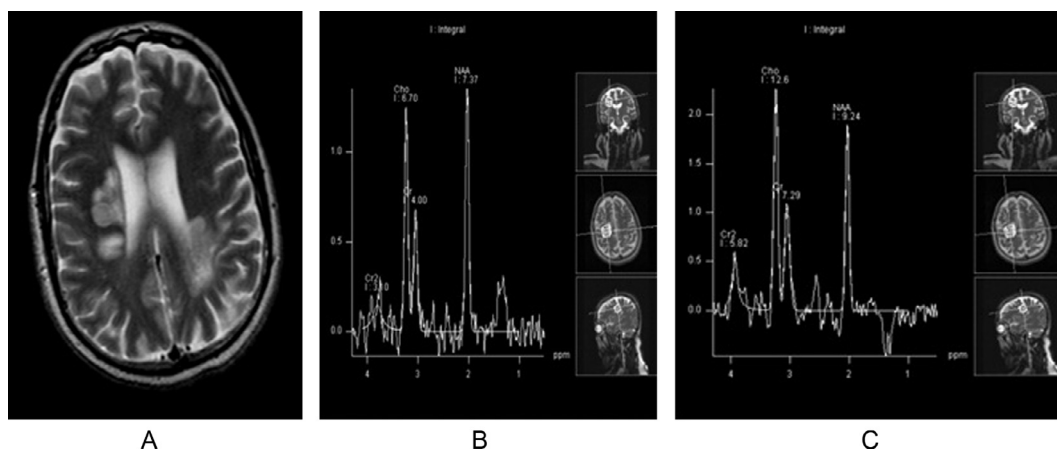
Female patient 28 years old with acute disseminated encephalomyelitis phase (A) Axial MRI brain T2 weighted images showed bilateral periventricular hyperintense lesions, (B) and (C) MRS at long and short TR showed: High choline/Cr, raised lactate peak, with no MI detected.
